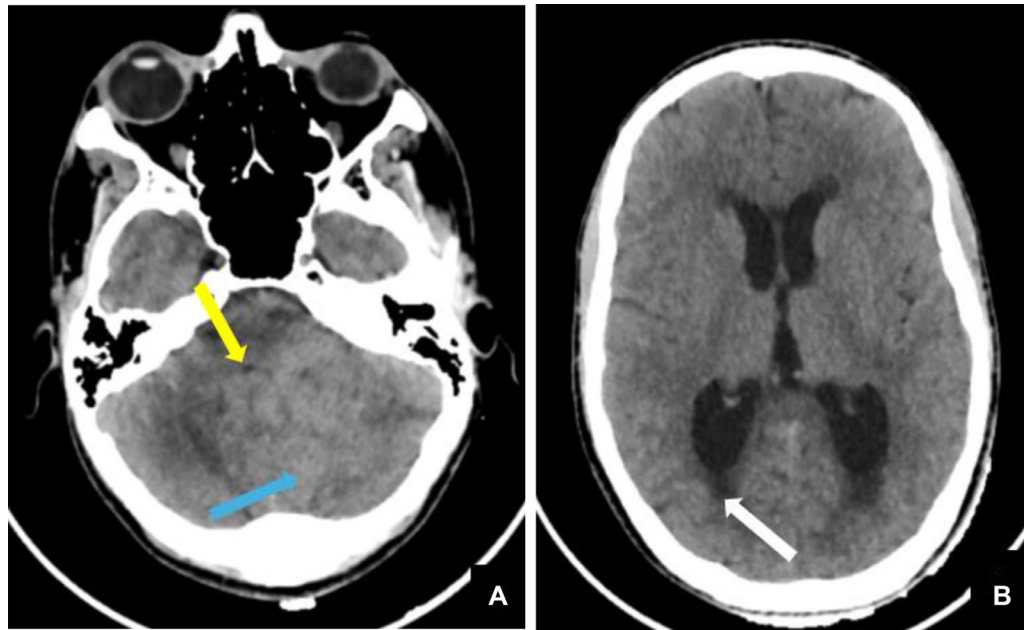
Precontrast CT scan reveals the presence of an expansive solid mass of the posterior cerebral fossa (blue arrow) with mass effect on the fourth ventricle (yellow arrow) (A). Trans endymal resorption (white arrow) (B).
